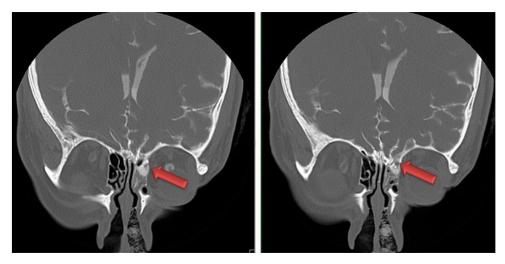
"CT cisternography: it reveals the contrast agent leaking from the subdural area to the right nasal fossa (red arrows)" (from *Turliuc et al. 2016b*)
